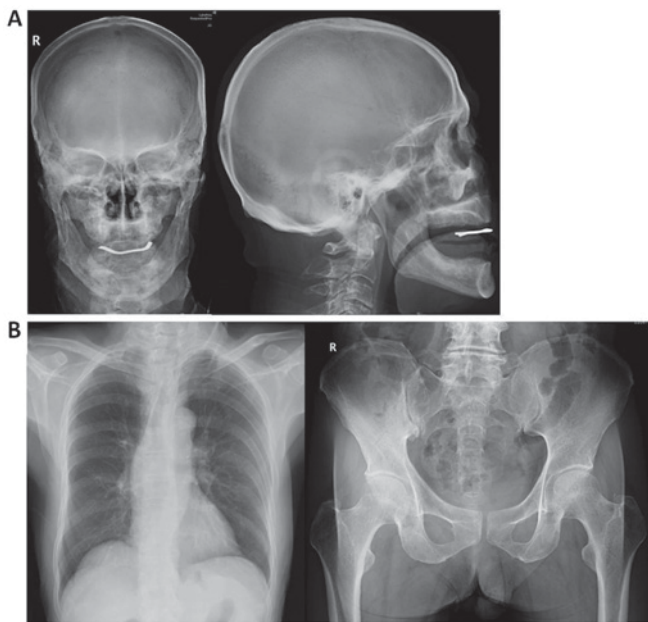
Radiographic representation. (A) Local cystic change on the parietal bone. (B) Normal chest and pelvic X-ray.
